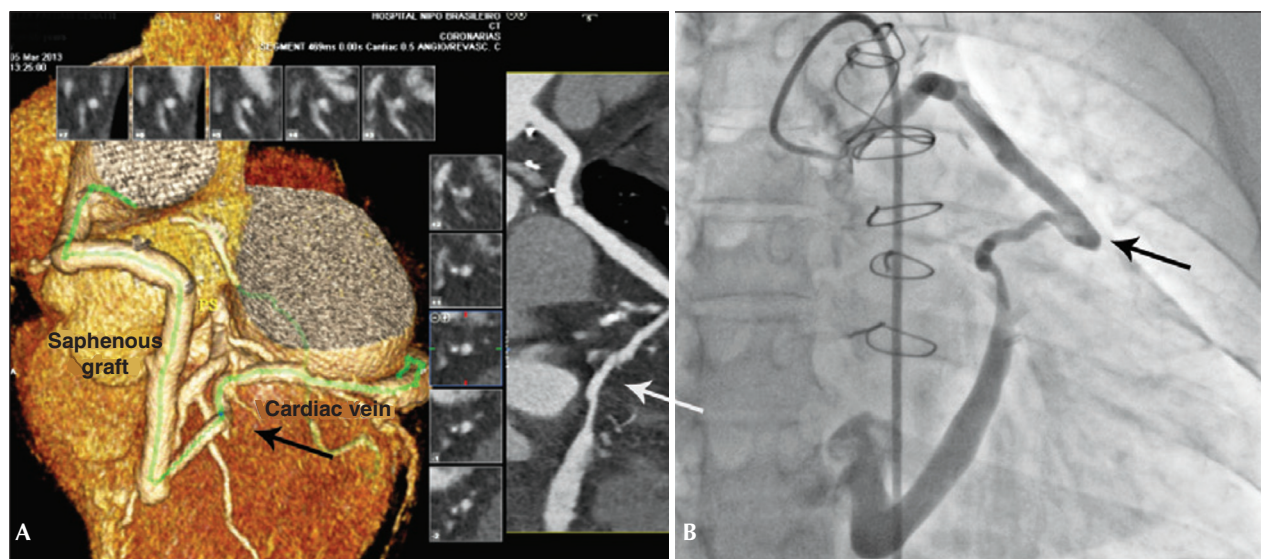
Case 1: CT angiography demonstrating patent and dilated saphenous vein graft, connected to the great cardiac vein (arrow) in the left anterior oblique view (A) and angiography of the same graft in the right anterior oblique view (B).
